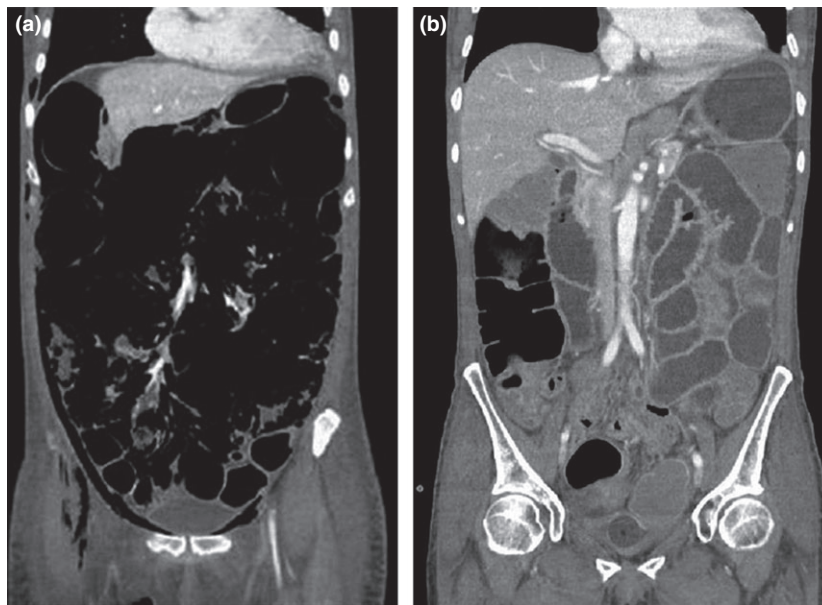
(a) Abdominal CT scan showing distension of small bowel with impressive diffuse intestinal wall pneumatosis, free air in the retroperitoneum and pneumoperitoneum, with associated subcutaneous emphysema. (b) Abdominal CT scan showing the resolution of the cysts with gas within the intestinal wall after hyperbaric oxygen therapy.
